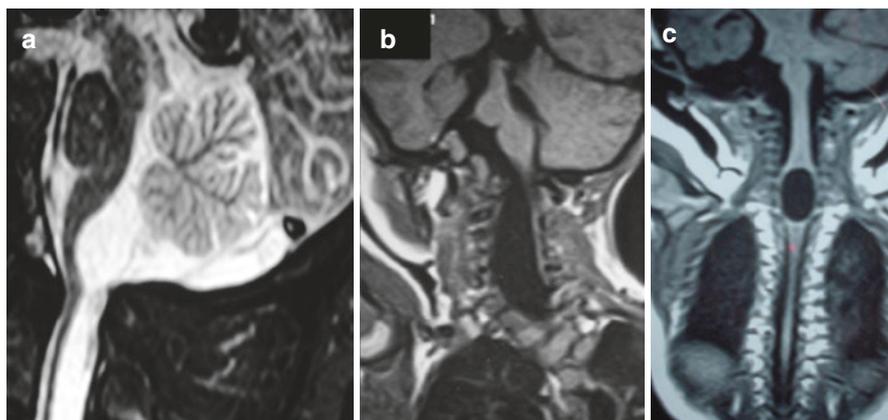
(a) T2 sagittal MR image of a posteriorly situated cyst compressing the medulla and cervical cord. (b) T1 coronal image showing a patient with cervical scoliosis and a cervicothoracic hemivertebra with an anterolateral cyst causing cervical cord thinning. (c) An intramedullary neurenteric cyst. (From Shukla et al. [14]; with permission)
